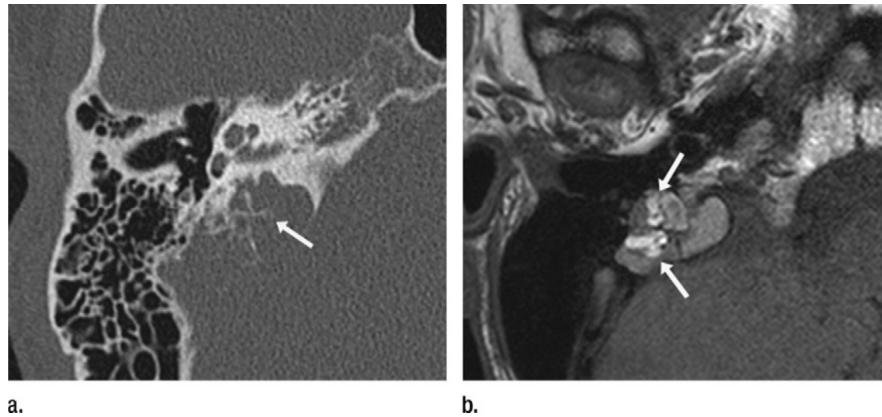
Axial Images of endolymphatic sac tumor (a) Axial CT image demonstrates an expansile lesion causing lytic bone destruction, centered around the vestibular aqueduct. Intratumoral spicules can be seen (arrow) (b) On nonenhanced T1-weighted MR image, areas of intrinsic T1 shortening are quite characteristic of this tumor (arrows). The tumor was resected by means of a translabyrinthine approach. (Juliano, 2013)
